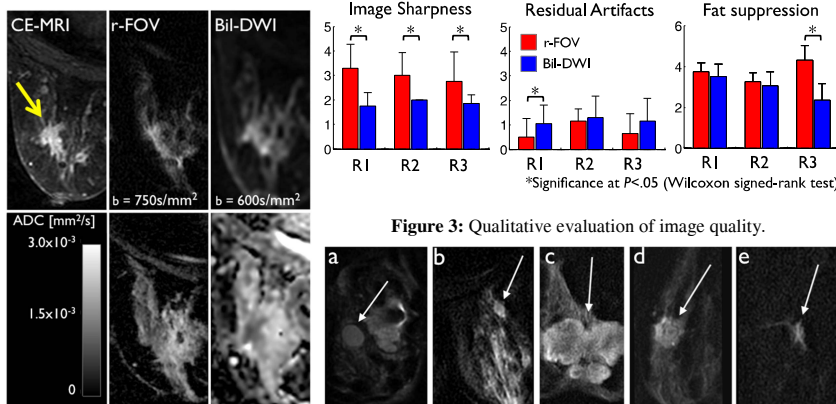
CE-MRI, r-FOV, bil-DWI and corresponding ADC values of a spiculated lesion.
